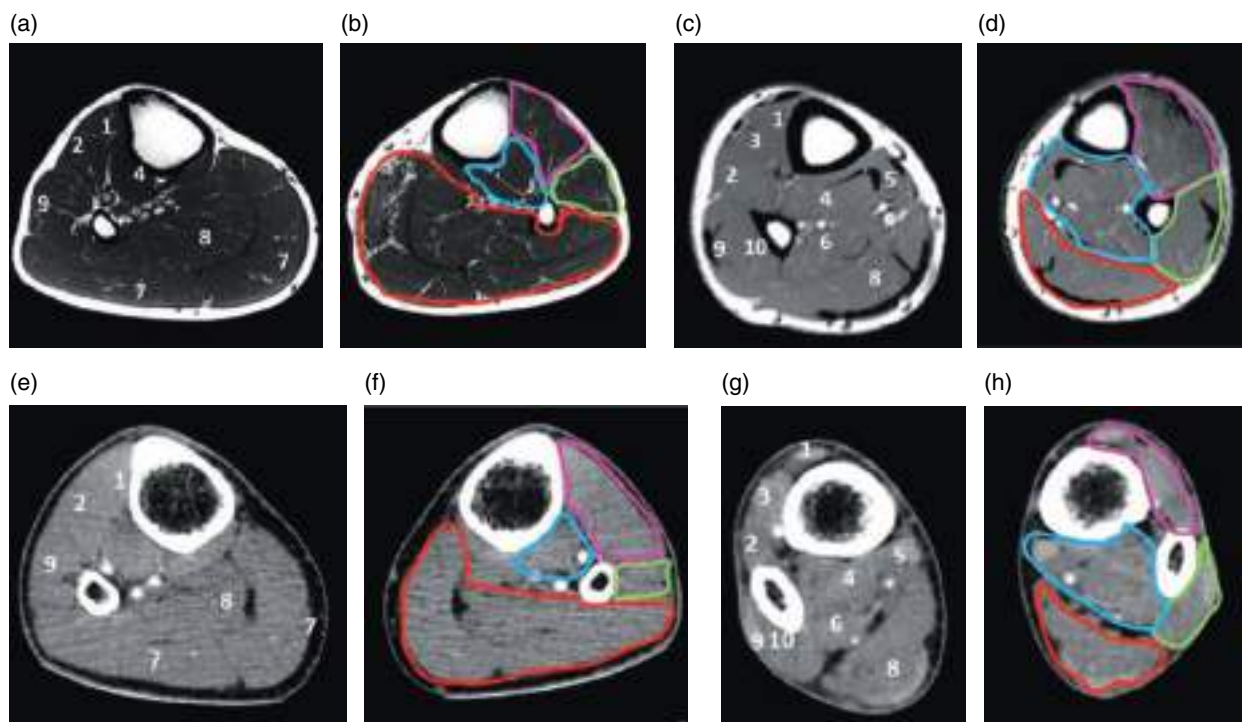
Compartments of the leg in MRI [(a and b) proximal and (c and d) distal] and in CT [(e and f) proximal and (g and h) distal]. The anterior compartment (pink) includes the tibialis anterior (1), extensor digitorum longus (2), and extensor hallucis longus (3) muscles. The tibialis posterior (4), flexor digitorum (5), and flexor hallucis longus (6) muscles lie in the deep posterior compartment (blue). The superficial posterior compartment (red) contains the gastrocnemius (7) and soleus (8) muscles (red). The peroneus longus (9) and brevis (10) make up the lateral compartment (green).
